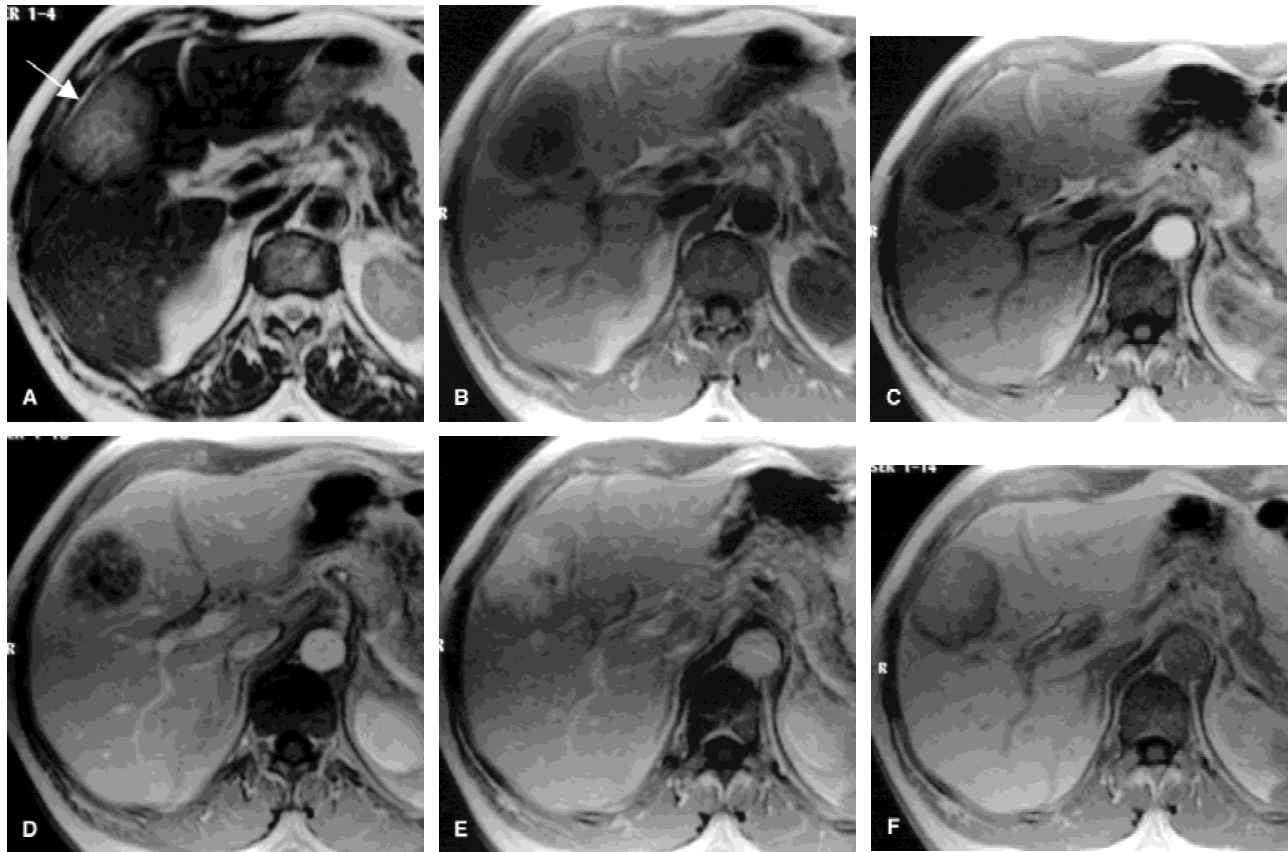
Peripheral cholangiocarcinoma in a 70-year-old man. a: TSE transverse T2-weighted image shows a large heterogeneous, slightly hyperintense lesion with blurred margins in the right lobe of the liver and capsular retraction (arrow). b: GRE transverse T1 precontrast image. The lesion is homogeneously hypointense to the surrounding liver parenchyma. c: During the arterial phase of dynamic imaging with bolus administration of Gd-BOPTA (GRE transverse T1-weighted), the lesion is homogeneously hypointense. d: In the portal venous phase, the lesion shows some enhancement with a lace-like pattern. e: In the distribution phase, the enhancement has become clearly evident. f: GRE transverse T1-weighted images obtained 2 hours after administration of Gd-BOPTA. Homogeneous enhancement of the liver is noted. The lesion shows accumulation of contrast media in the desmoplastic area, with a peripheral zone of washout.
